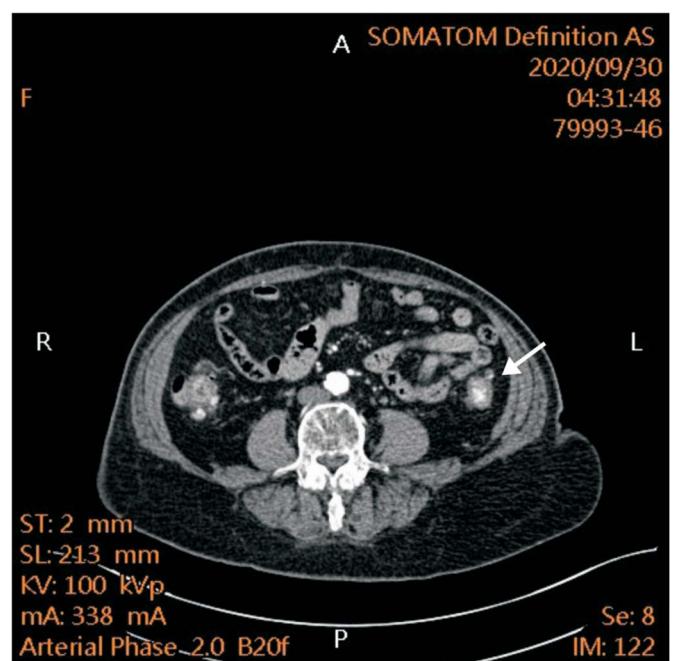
CTA revealed contrast extravasation in descending colon with some contrast within nearby diverticulum.
